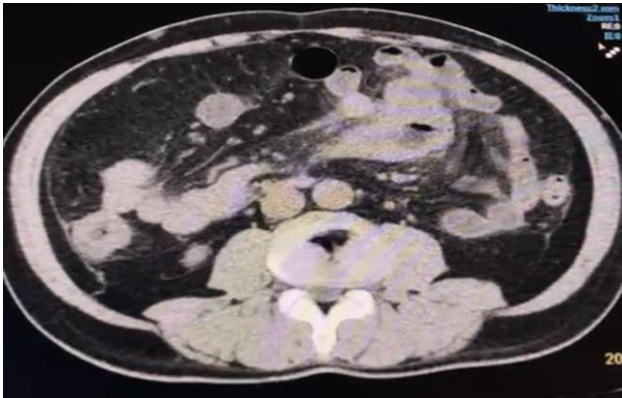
Axial abdominal CT-scan, inflammation of the mesentery is present in the left lower quadrant, an image of a tumor like mass is present with hypodense areas in the left quadrant.
